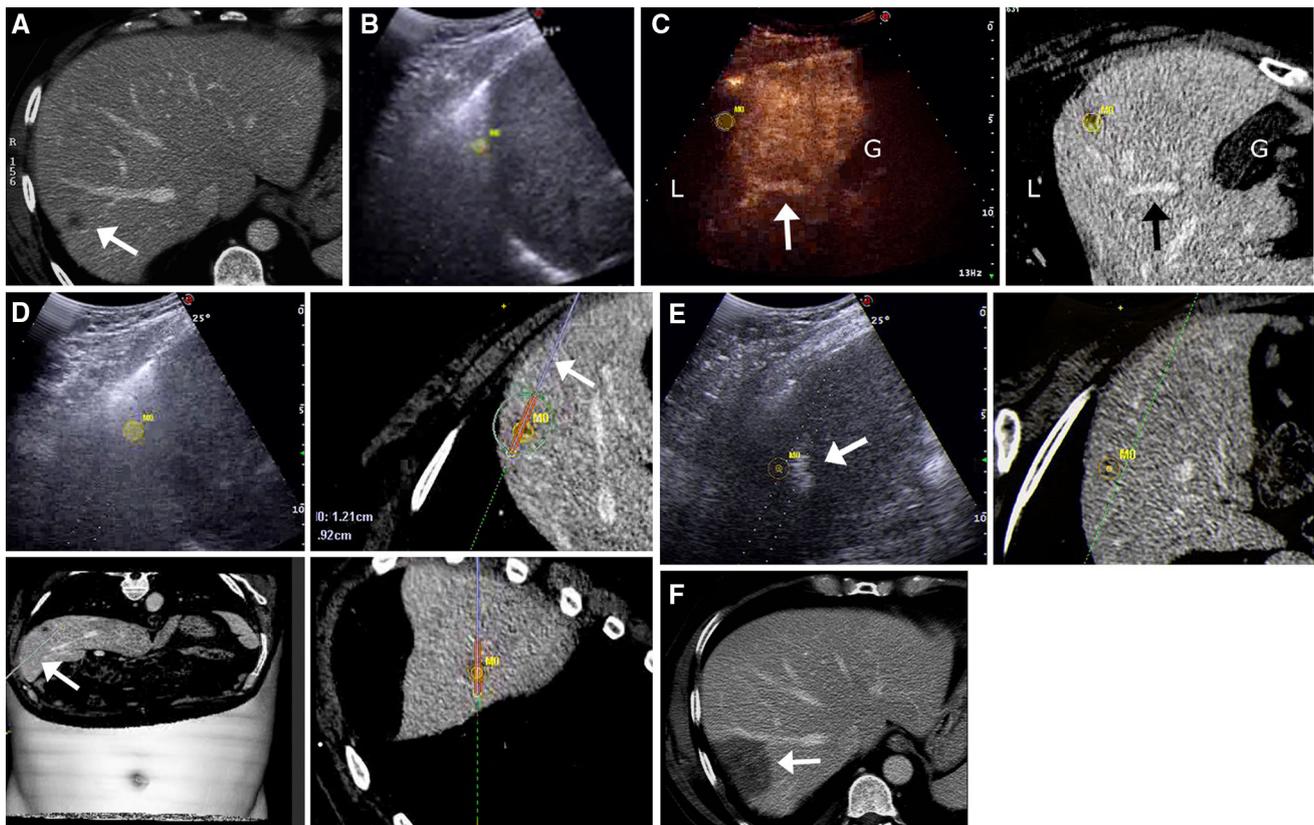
Real-time, US-CT image fusion for guidance of thermal ablation of colorectal liver metastasis detected by contrast-enhanced CT (arrow, A), but undetectable by US and CEUS (left side, B), being hidden by air lung due to its location. With image fusion the lesion is clearly seen on CT (right side, B) (yellow circle virtual target; L lung; G gallbladder; arrow portal vein branch). Radiofrequency electrode is inserted into the target under the guidance of CT scan as a reference
